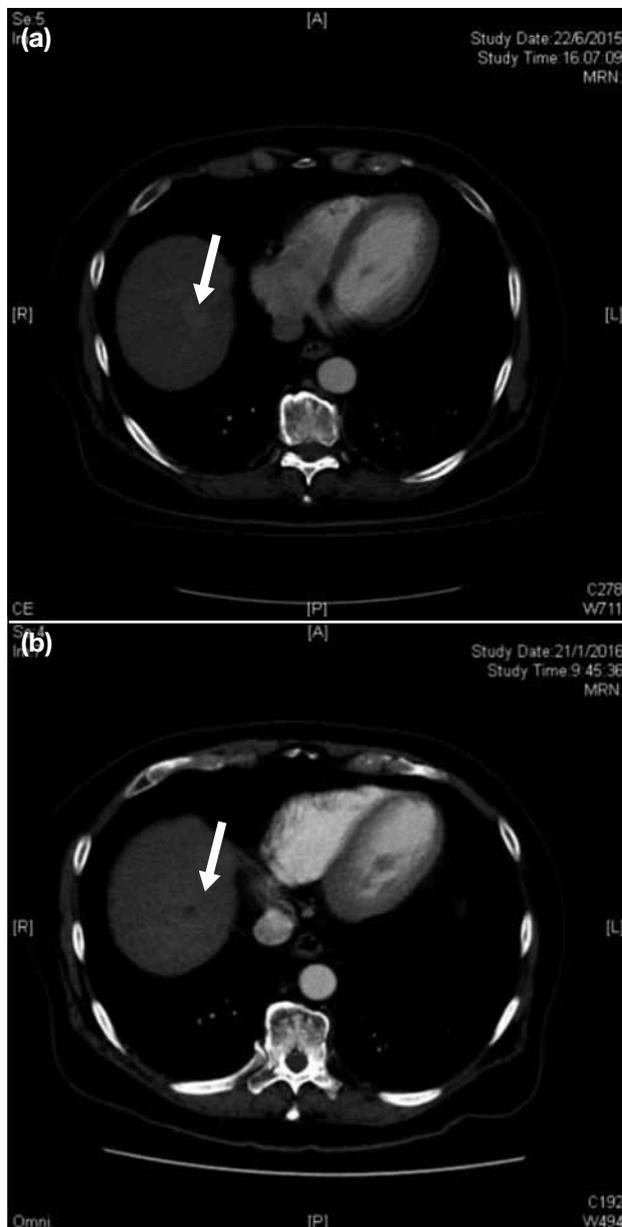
In a 65-year-old man with cryptogenic cirrhosis secondary to non-alcoholic steatohepatitis who underwent stereotactic body radiation therapy (SBRT) before liver transplantation, computed tomography showing (a) an arterially enhancing nodule (measuring 2.1 x 1.5 x 1.7 cm) with contrast washout in segment VIII of the liver near the dome (arrow) before SBRT, and (b) a hypodense lesion of 1 cm (arrow) that is hypoenhancing in all dynamic phases 3 months after SBRT.
